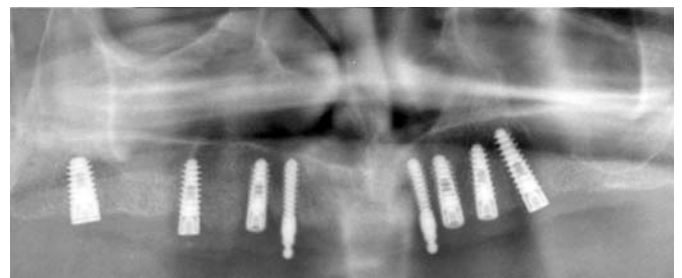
Case 1. Orthopantomograph after implant placement.
